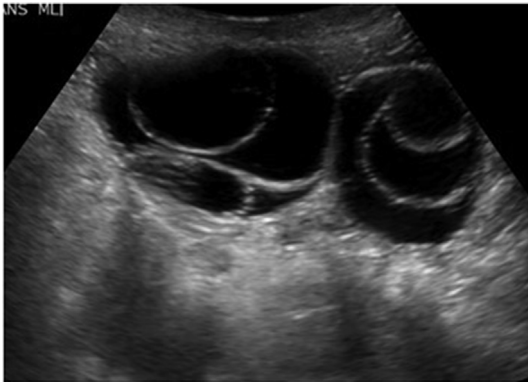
Patient's ultrasound showing bilateral cystic ovaries.
